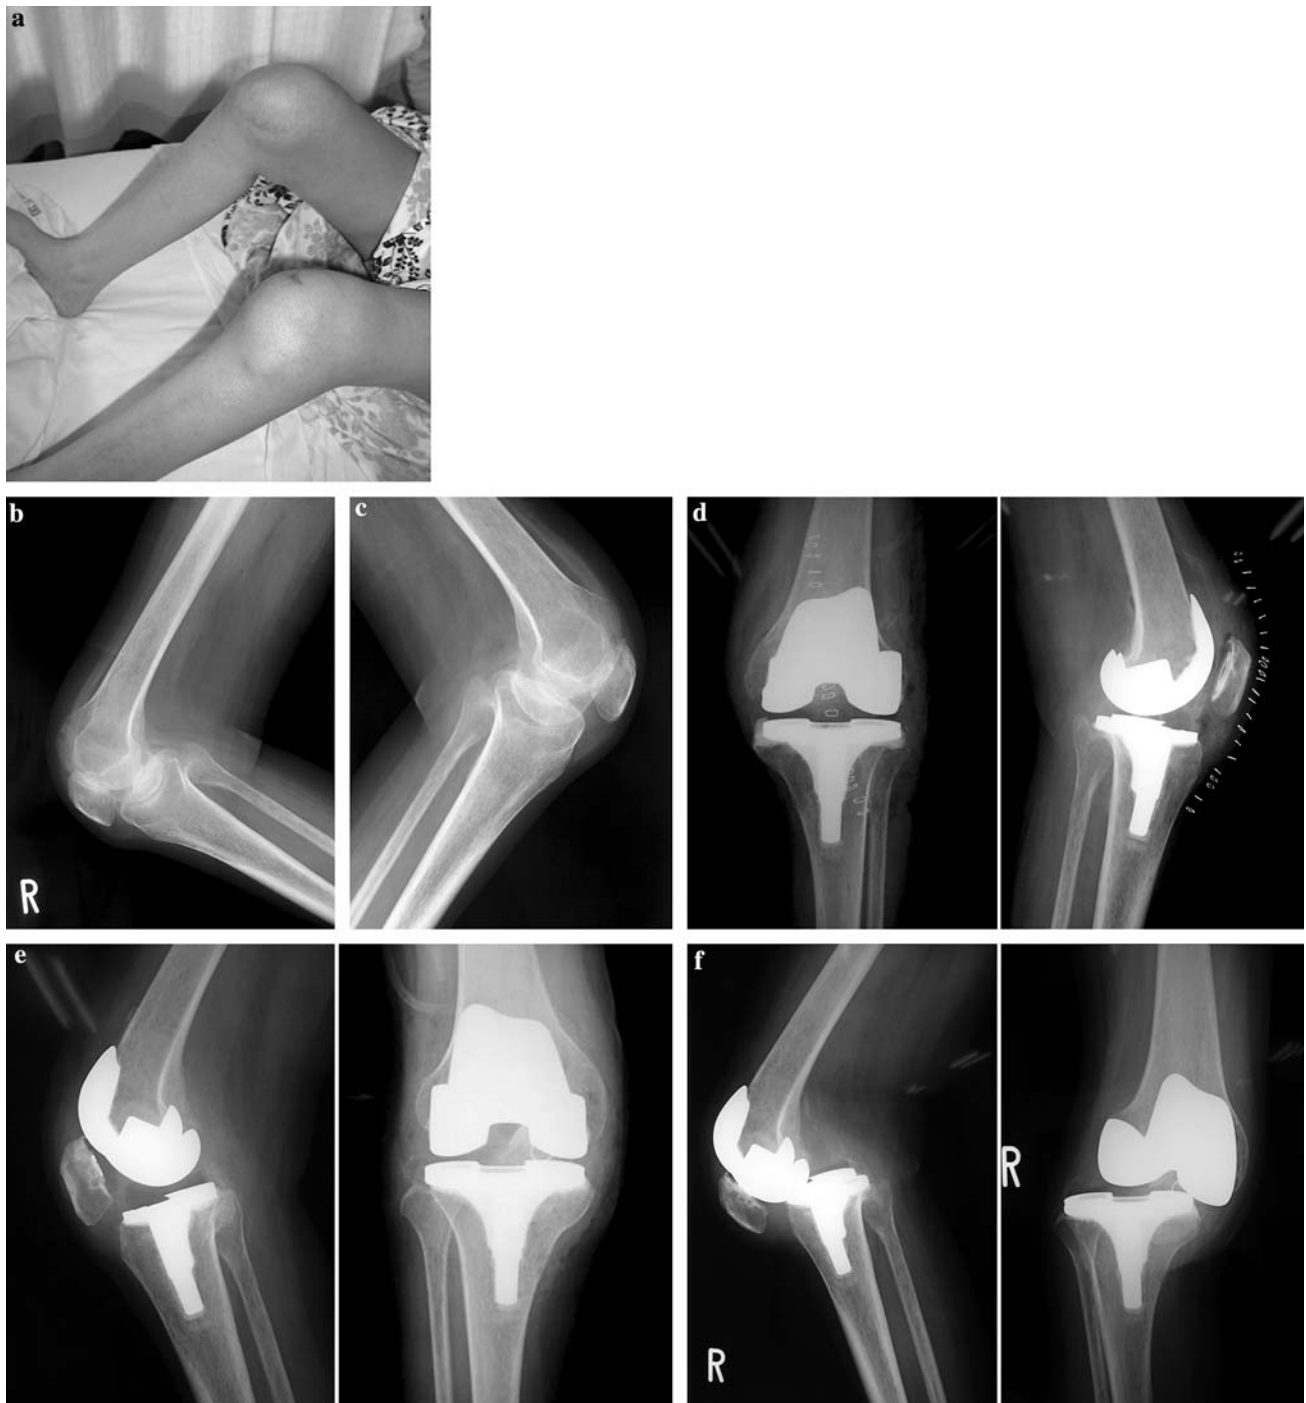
Patient 1. a Preoperative condition of the lower limbs in patient 1. b Plain lateral radiograph of the right knee reveals marked patellar baja. c Plain lateral radiograph of the left knee. d Plain anteroposterior, lateral radiograph of the left knee after TKA. e Plain
